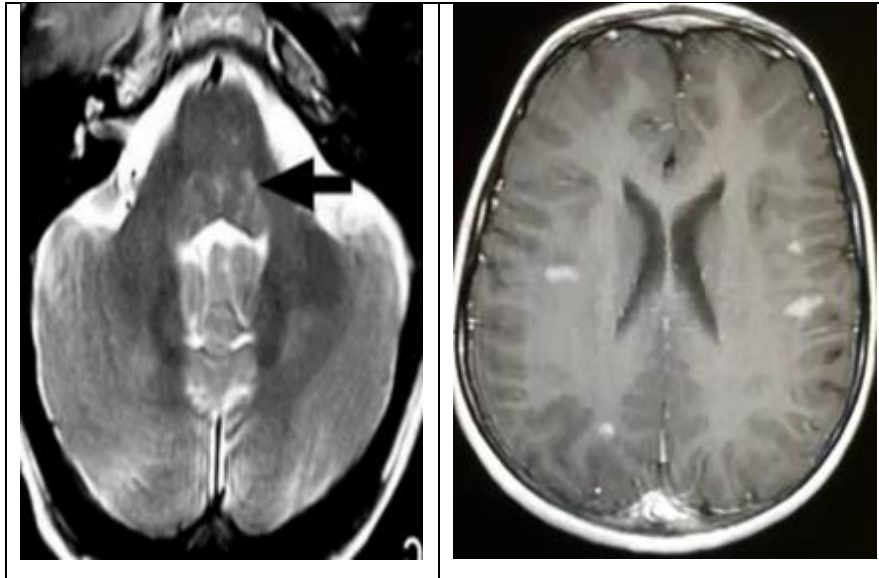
Multiple active demyelinating lesions on MRI with involvement of the right sixth nerve
